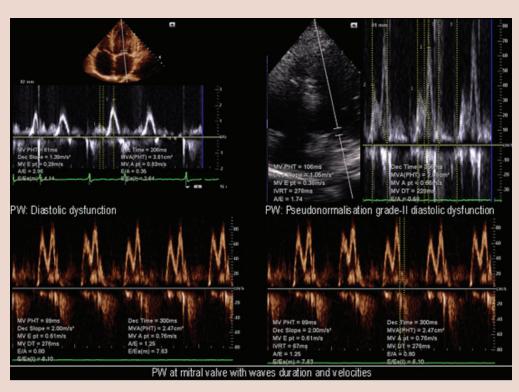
Echocardiography and Doppler study showing parameters of PW in diastolic dysfunction.
